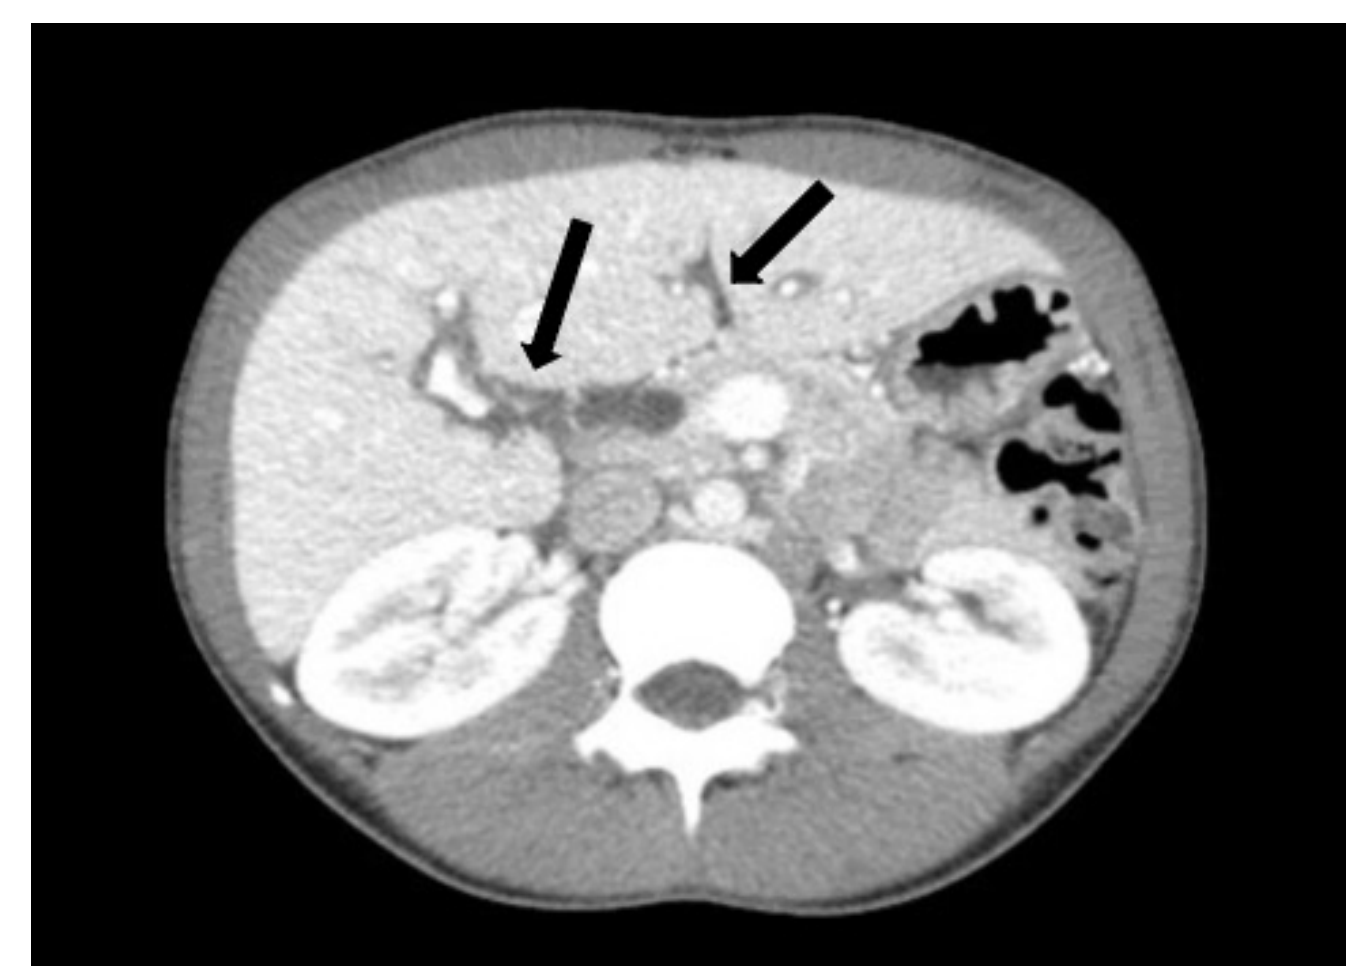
CT Abdomen/Pelvis demonstrating intrahepatic and extrahepatic biliary ductal dilation with possible stones within the distal common bile duct
